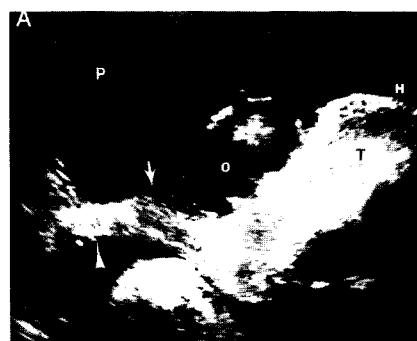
Sonographic finding in acardiac twins, showing hydropic fetus without head, and also omphalocele.
